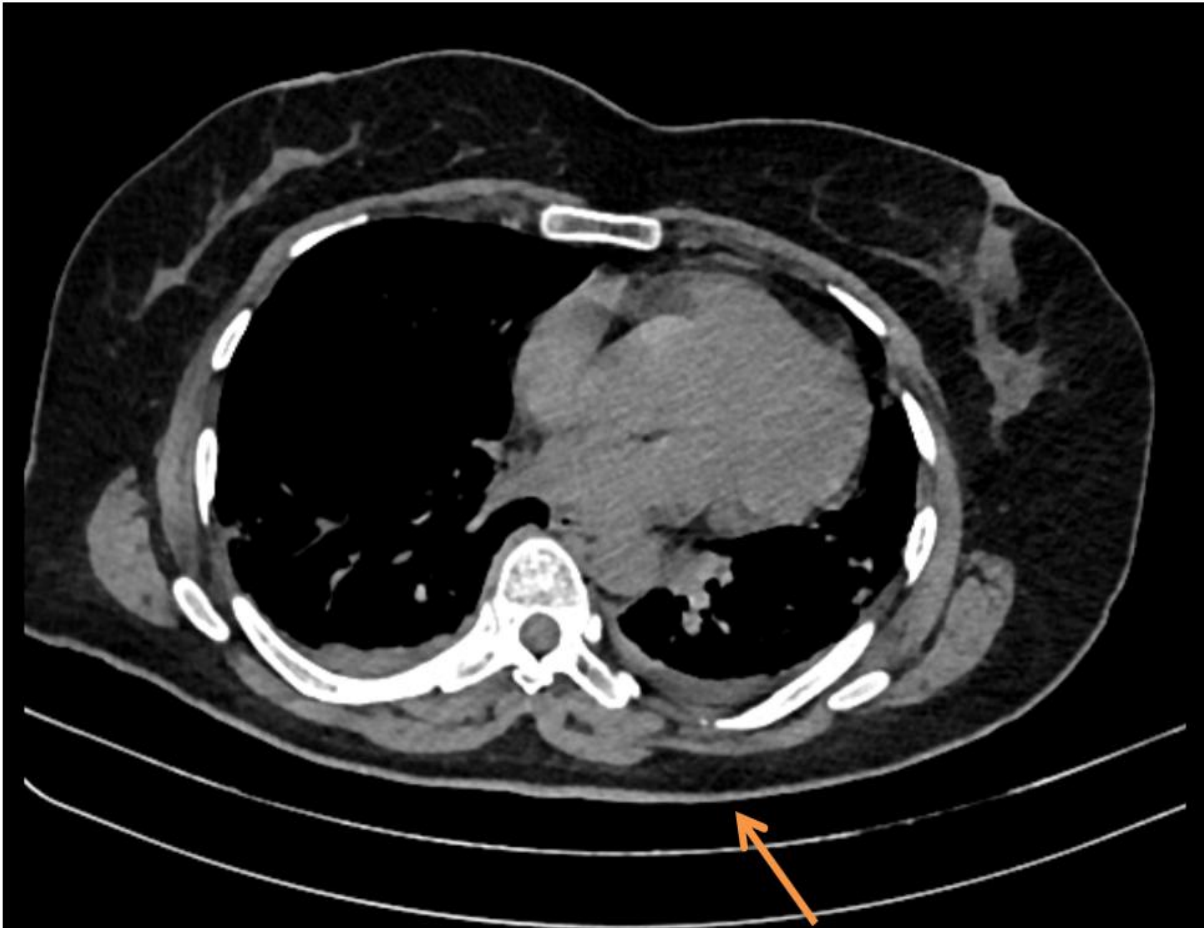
CT chest showing bilateral pleural effusion
